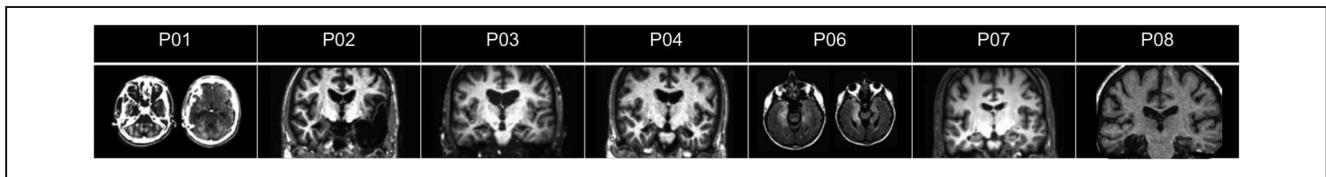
Structural MRI and CT scans depicting MTL lesions for seven of the eight amnesic participants. The left side of the brain is displayed on the right side of the image. CT slices show lesion location for P1 in the axial plane. T1-weighted MRI images depict lesions for P2, P3, P4, P7 and P8 in the coronal plane. T2 flair MRI images depict lesion locations for P6 in the axial plane. (The image for P08 was modified from Kwan, Kurczek, & Rosenbaum, 2016, with permission.)
